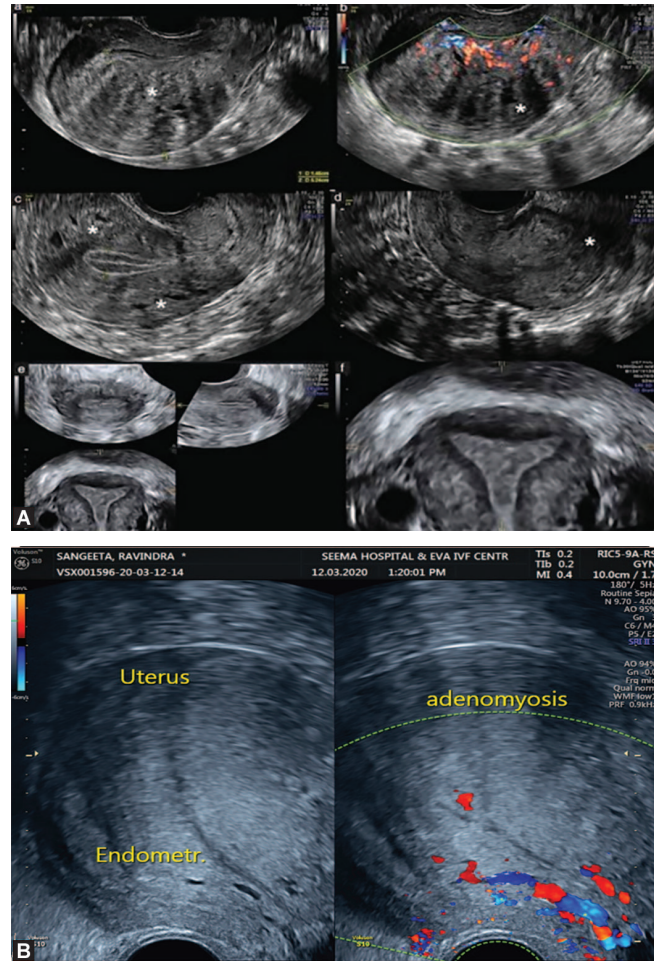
USG and Doppler image of adenomyosis uterus showing diffuse asymmetric thickening of uterine wall and increased myometrial vascularity
